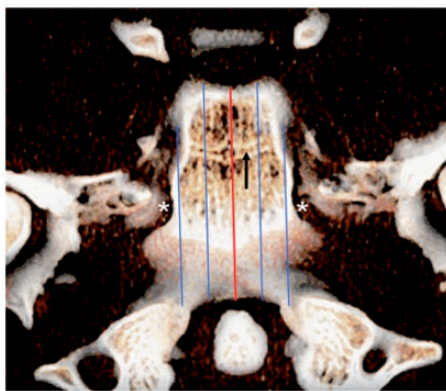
Skull base anatomy. Axial plane: infant skull base – CT volume rendering technique (VRT) reconstruction. Definition of three parallel-oriented zones (blue lines) to each side of the clival midline (red line) to evaluate the extent of clival tumor erosion. Arrow: sphenoid-occipital synchondrosis. Asterisk: petroclival (petroclival) synchondrosis.
